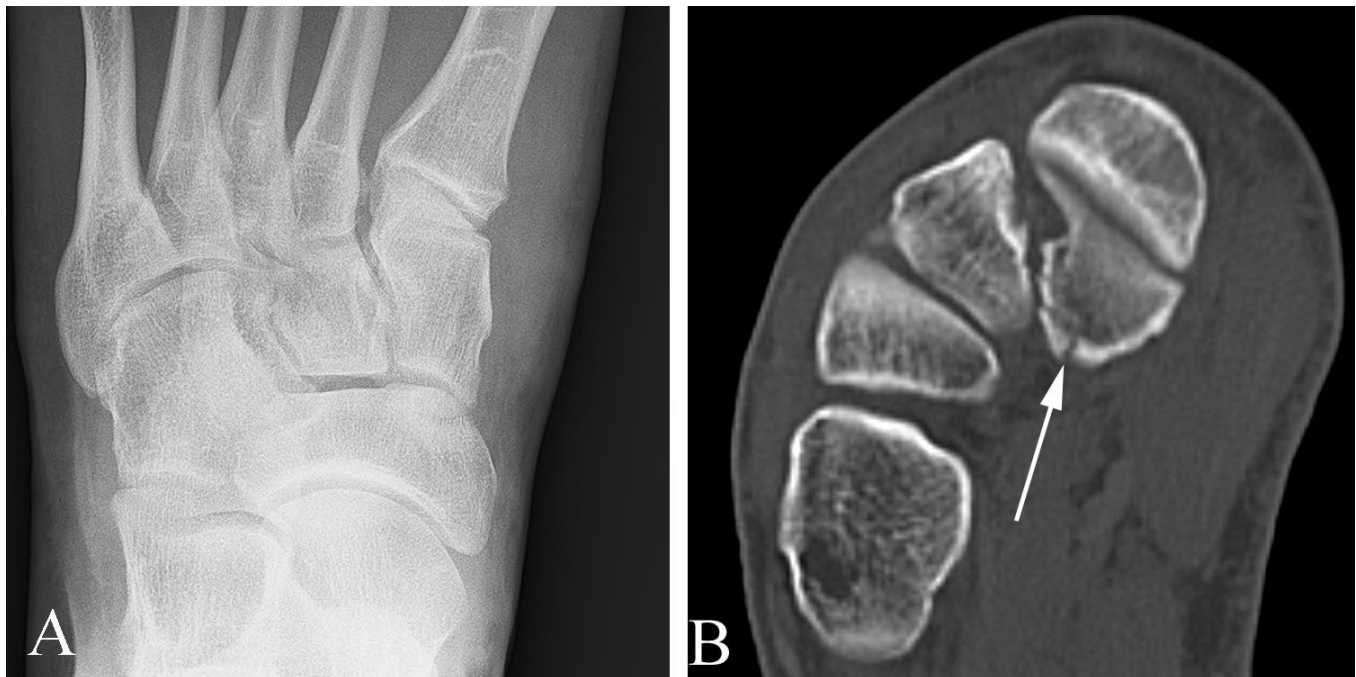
Occult (on plain films) cuneiform fracture in a 22 year old man with foot pain following trauma. A. Oblique plain film of the foot is normal. B. Axial CT examination shows a fracture through the medial cuneiform (arrow).
